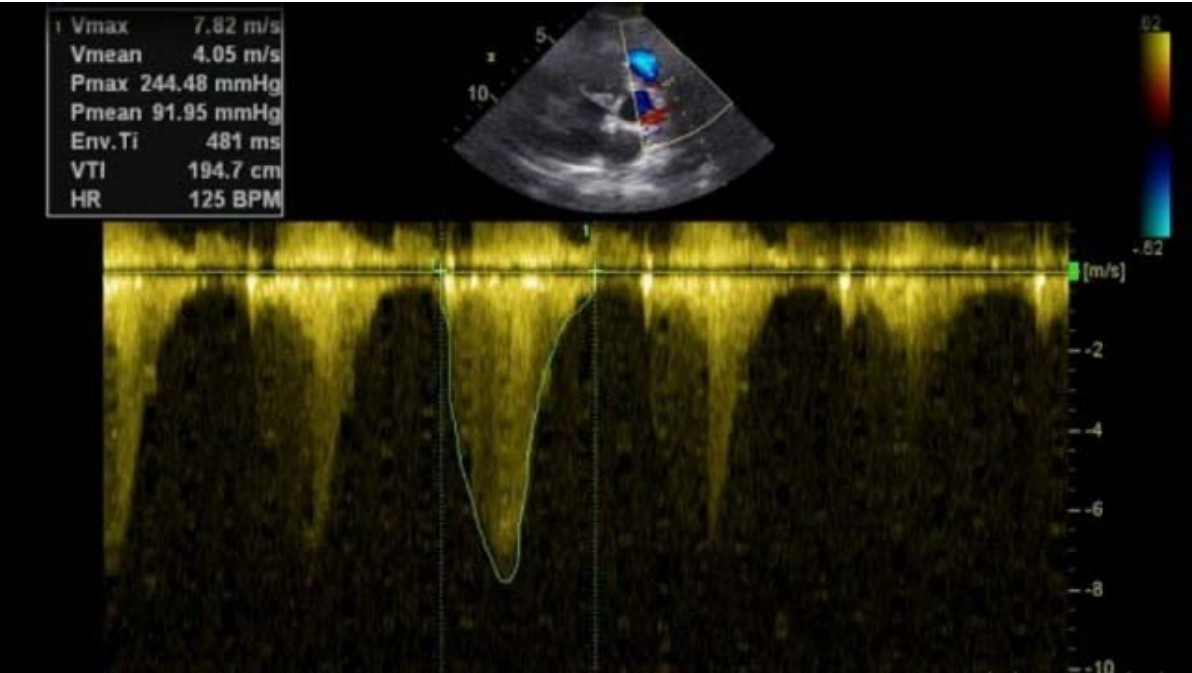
Right ventricular view on echocardiography
